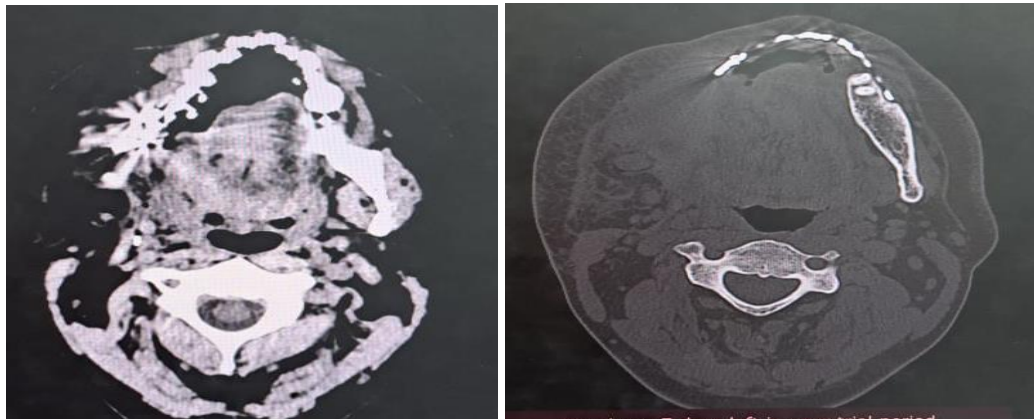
Images from facial CT scan after right mandibulectomy
